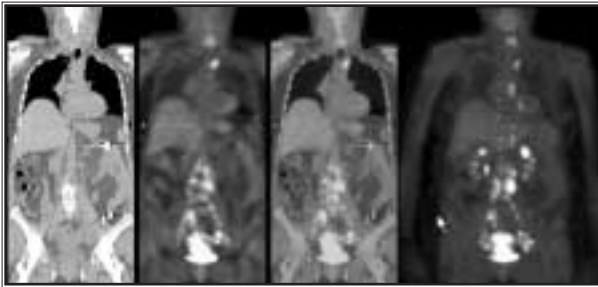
47-year-old woman with bladder wall invasion, hydronephrosis, extensive pelvic adenopathy, and a possible para-aortic adenopathy. Coronal CT, PET, fused, and MIP images from the patient's PET/CT show unsuspected retrocrural, mediastinal, and left hilar adenopathy as well as intense activity in primary tumor extending well into the uterus and known and suspected para-aortic pelvic lymph node metastases.
